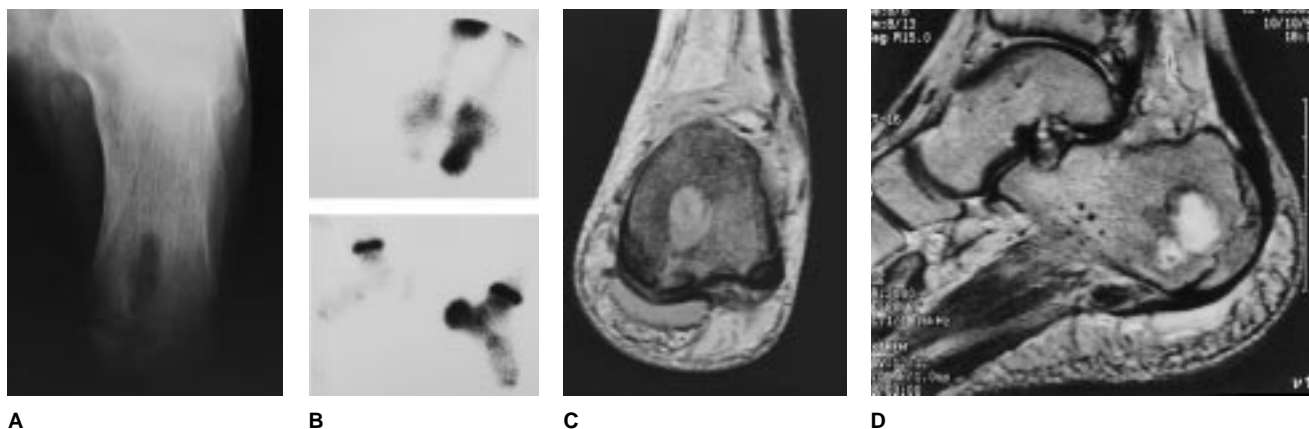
Images of a 12-year-old boy with a history of vague, intermittent, poorly localized ankle and hindfoot pain for several years and a recent acute exacerbation. Further questioning disclosed an untreated puncture wound to the heel 4 years previously. A, Radiograph demonstrates a lytic defect in the calcaneus. B, Anteroposterior (top) and lateral (bottom) bone scans show markedly increased uptake in the calcaneus. C and D, MR images show fluid in the calcaneus, with erosion through the cortex, and a medial heel abscess. The patient improved after surgical drainage and long-term intravenous antibiotic therapy.
